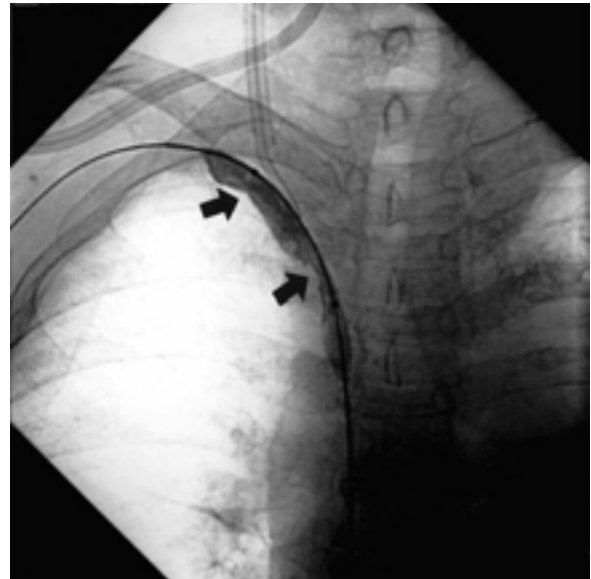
Radiograph shows a formation of two waists (arrows) during the inflation of a balloon catheter with a diameter of 14 mm.
